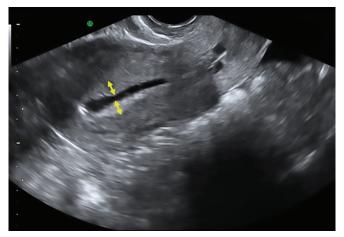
Saline infusion sonography demonstrates diffuse endometrial thickening (the measurement of both single layers at their thickest level is 12 mm)
